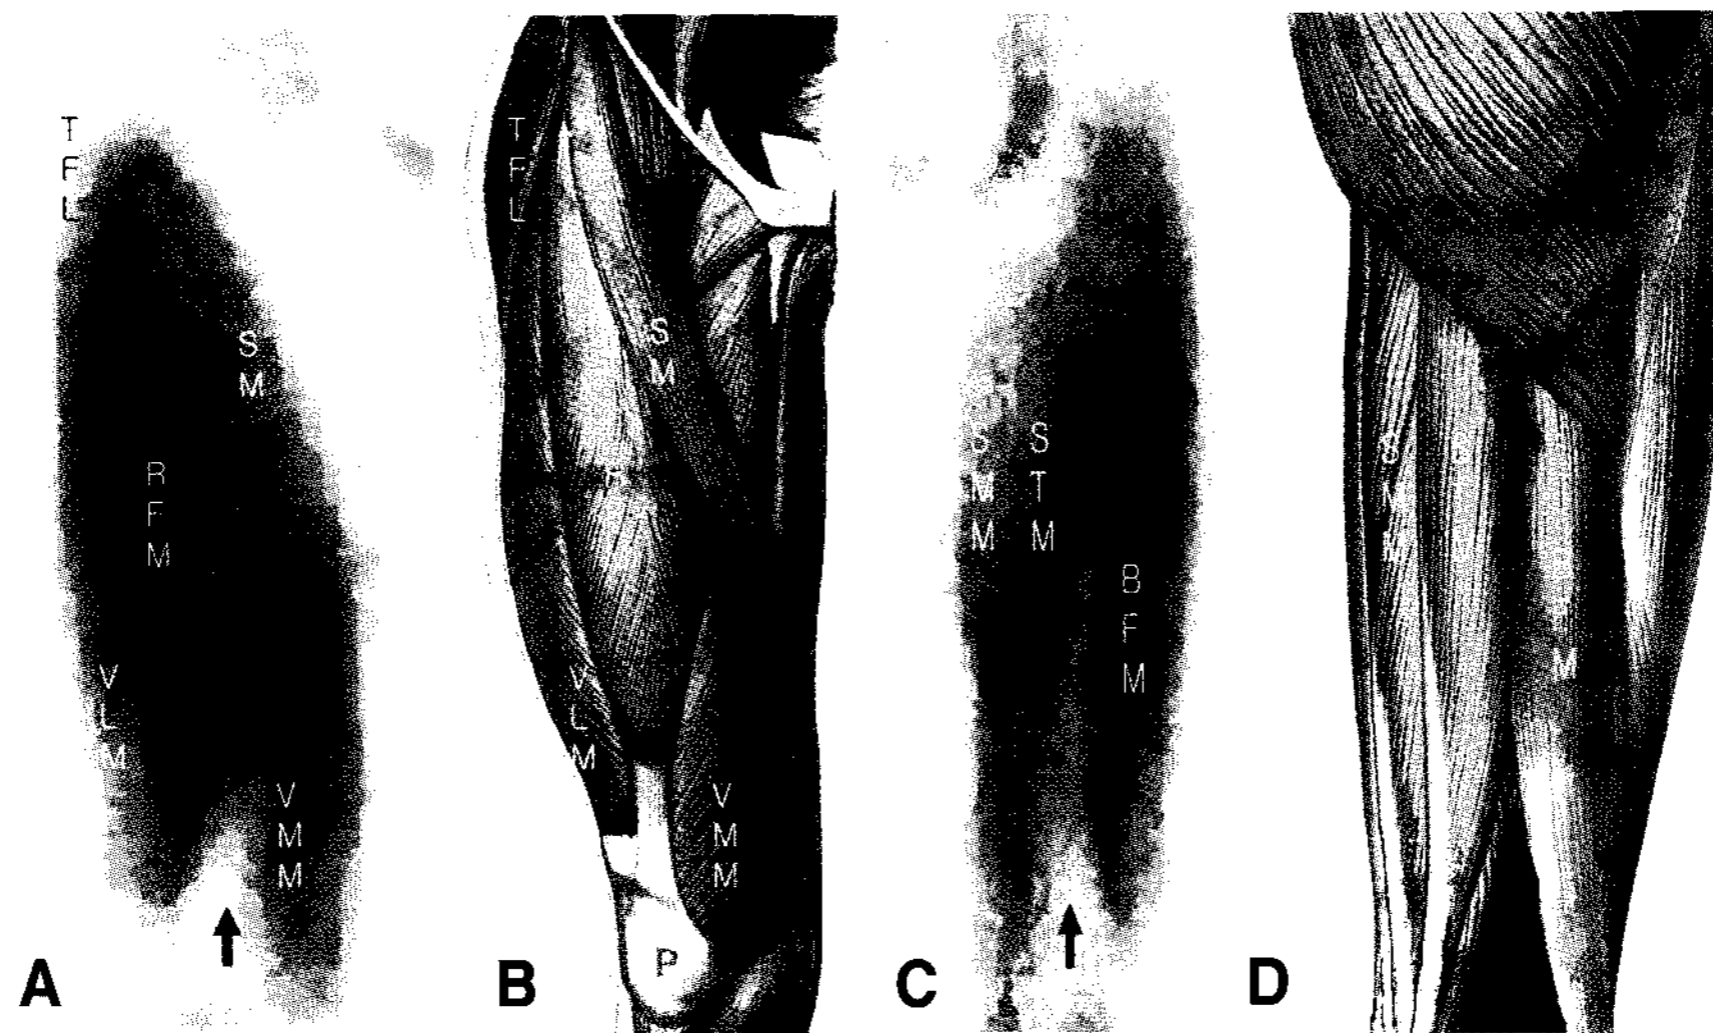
(A) Magnified anterior scan of right thigh identifies tensor fasciae latae (TFL), sartorius muscle (SM), rectus femoris muscle (RFM), vastus lateralis muscle (VLM) and vastus medialis muscle (VMM). Arrow denotes the distal femur. (B) Topograph. P is patella (C) Magnified posterior scan of right thigh identifies semimembranosus muscle (SMM), semitendinosus muscle (STM) and biceps femoris muscle (BFM). Arrow denotes distal femur. (D) Topograph. P is patella. Adapted with permission from Sobotta: Atlas der Anatomie des Menschen. © Elsevier GmbH, Urban & Fischer Verlag Munich. (CT/sma/March2008).
